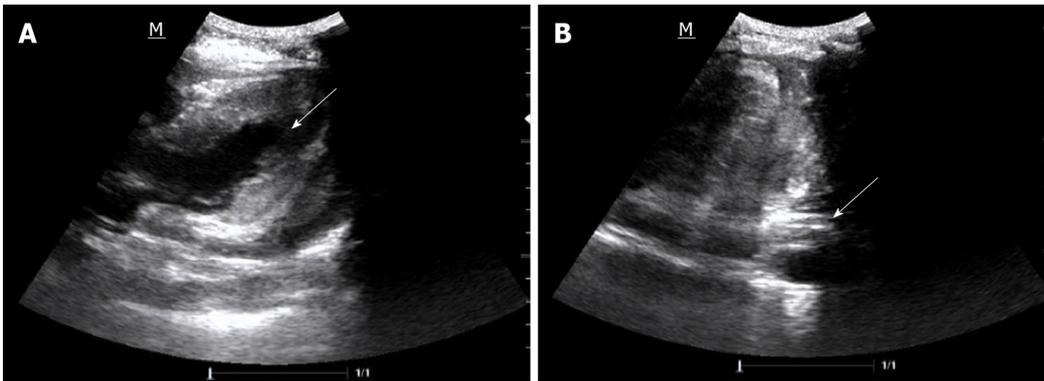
Bedside cardiac ultrasound images. A: Pericardial effusion (arrow); B: A large number of pericardial blood clots (arrow).
